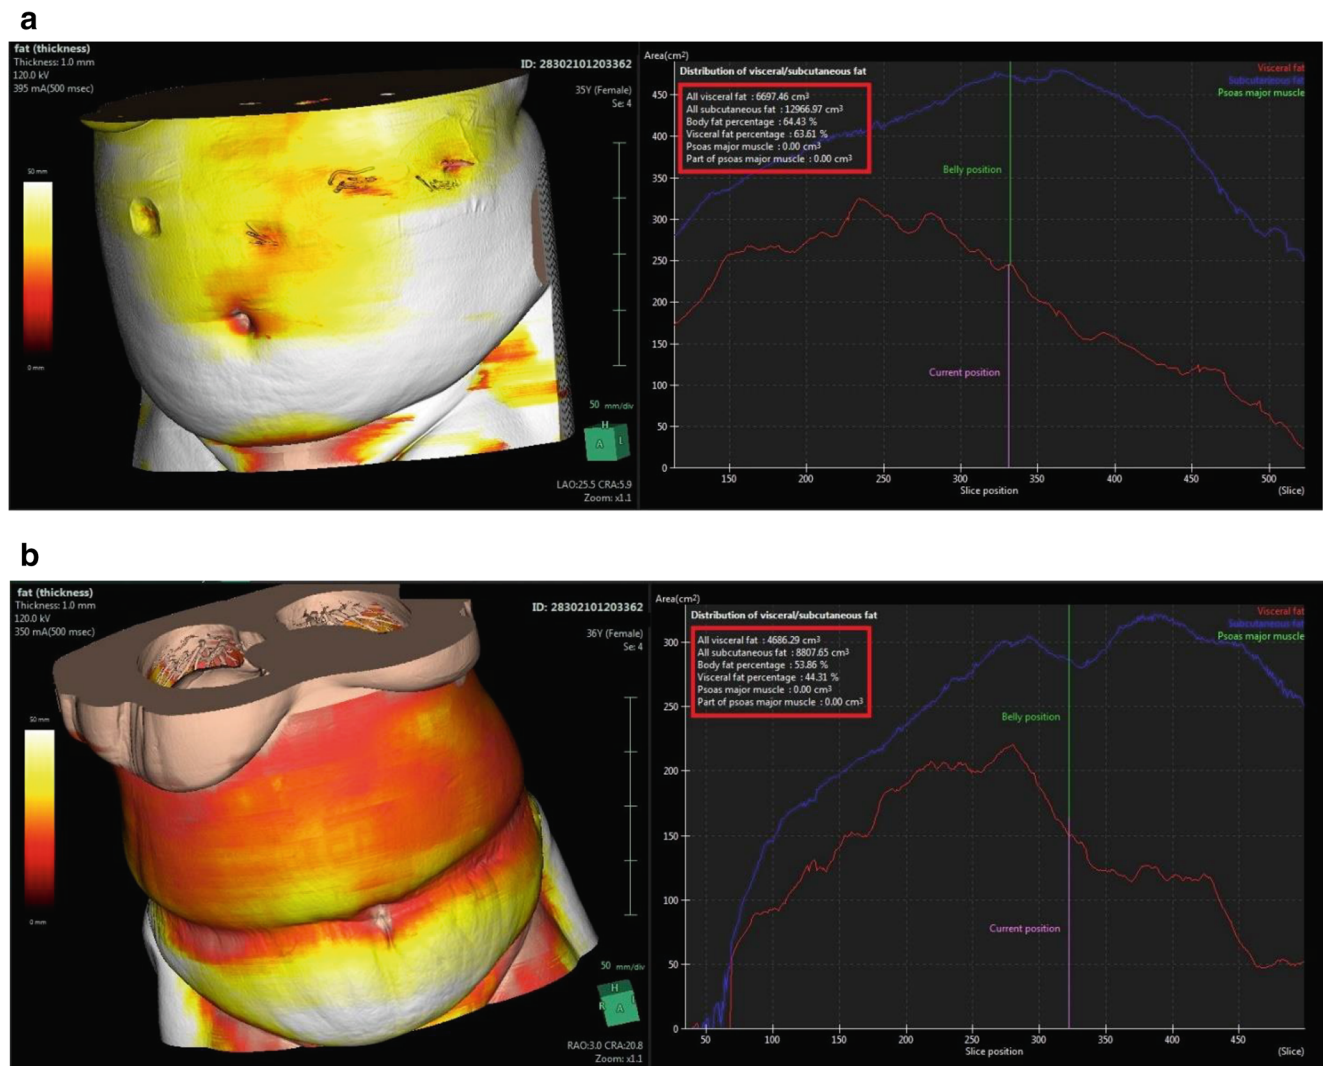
Abdominal CT (3D) in a laparoscopic OAGB patient: (a) before operation; (b) 6 months after operation
